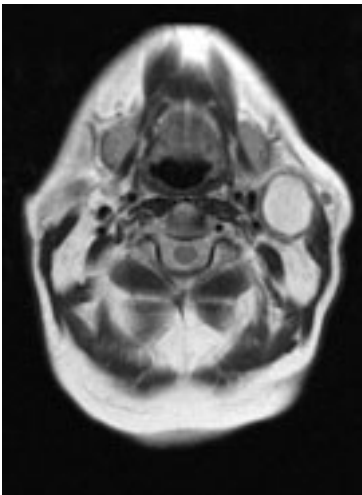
Unenhanced T2-weighted MR image of a branchial cleft cyst in the left submandibular region. The center of the cyst is markedly hyperintense, and the cyst wall shows intermediate signal intensity. The sternocleidomastoid muscle has been displaced posterolaterally, the neurovascular sheath medially.
